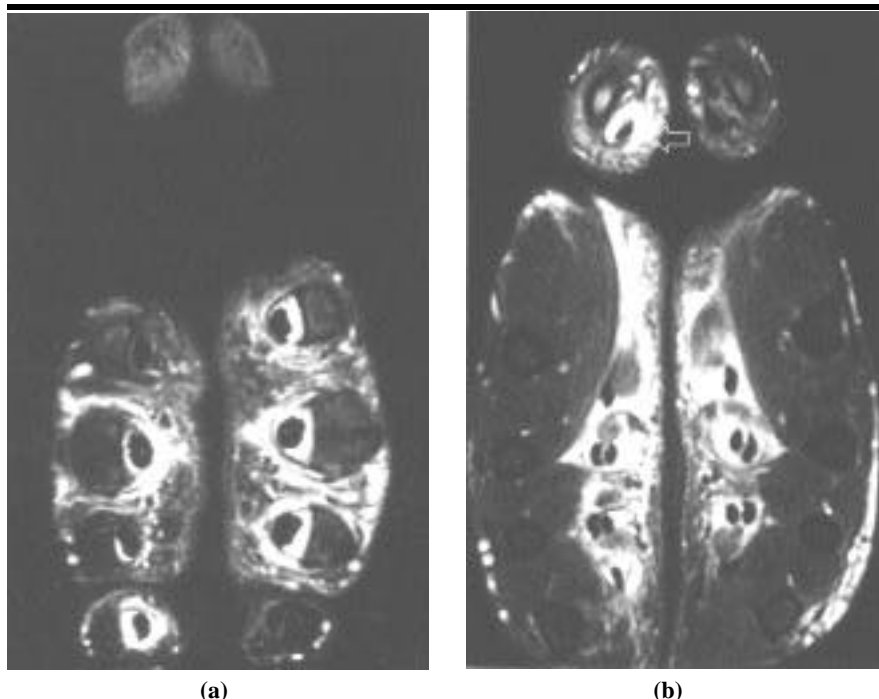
(a) T2-weighted image at the level of the proximal interphalangeal joints showing fluid in the synovial sheaths of the 3rd, 4th and 5th left fingers and in the 2nd, 3rd and 4th right fingers. (b) T2-weighted image at the level of the metacarpophalangeal joints showing also the involvement of the 1st left finger (arrow).
